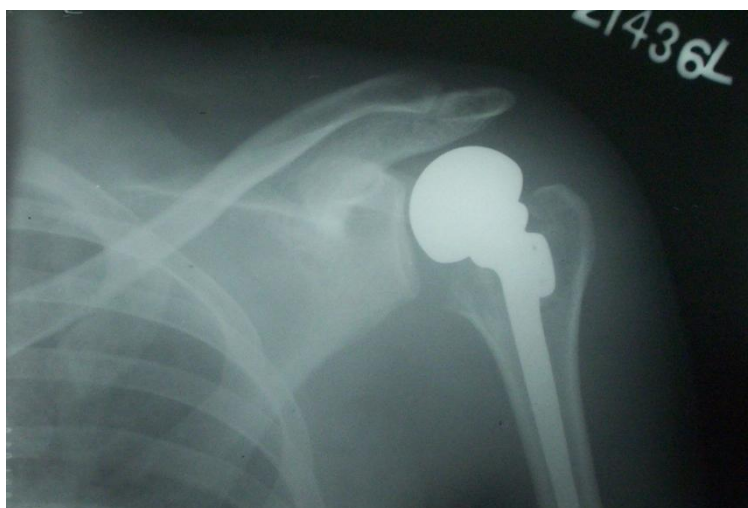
post op x-ray revealing prosthesis insertion
